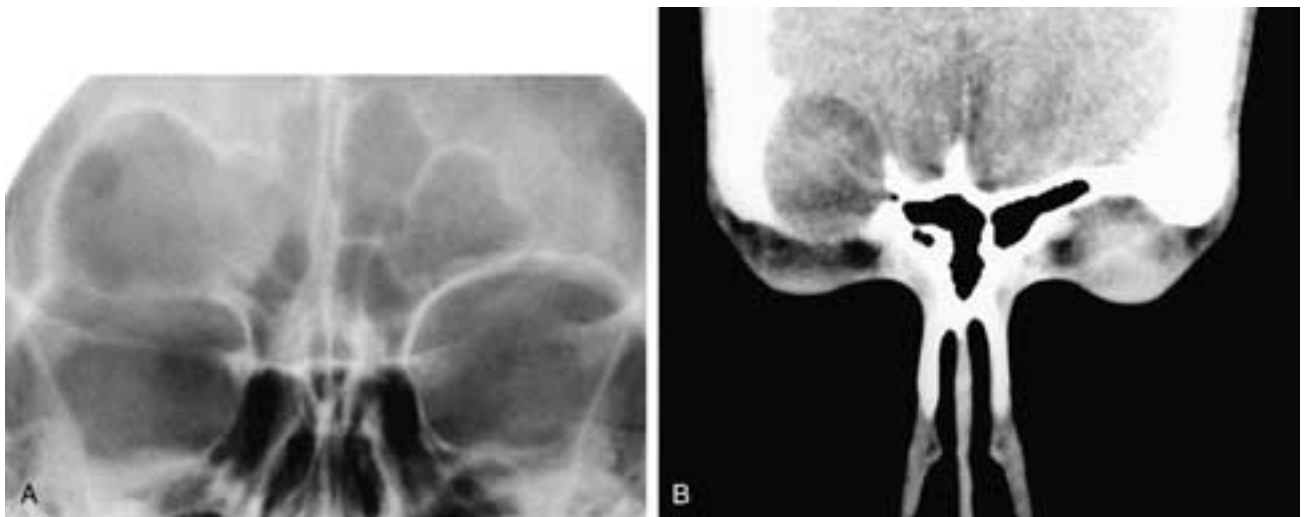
Caldwell view (A) shows a smoothly expansile lesion in the lateral right frontal bone, which is thinning and depressing the right orbital roof. A thin white mucoperiosteal line surrounds the mass. Coronal CT scan (B) shows the localized, expansile, homogeneously 'mucoïd' attenuation mass, which is depressing the right orbital roof. This patient has a cholesteatoma of the frontal bone.
